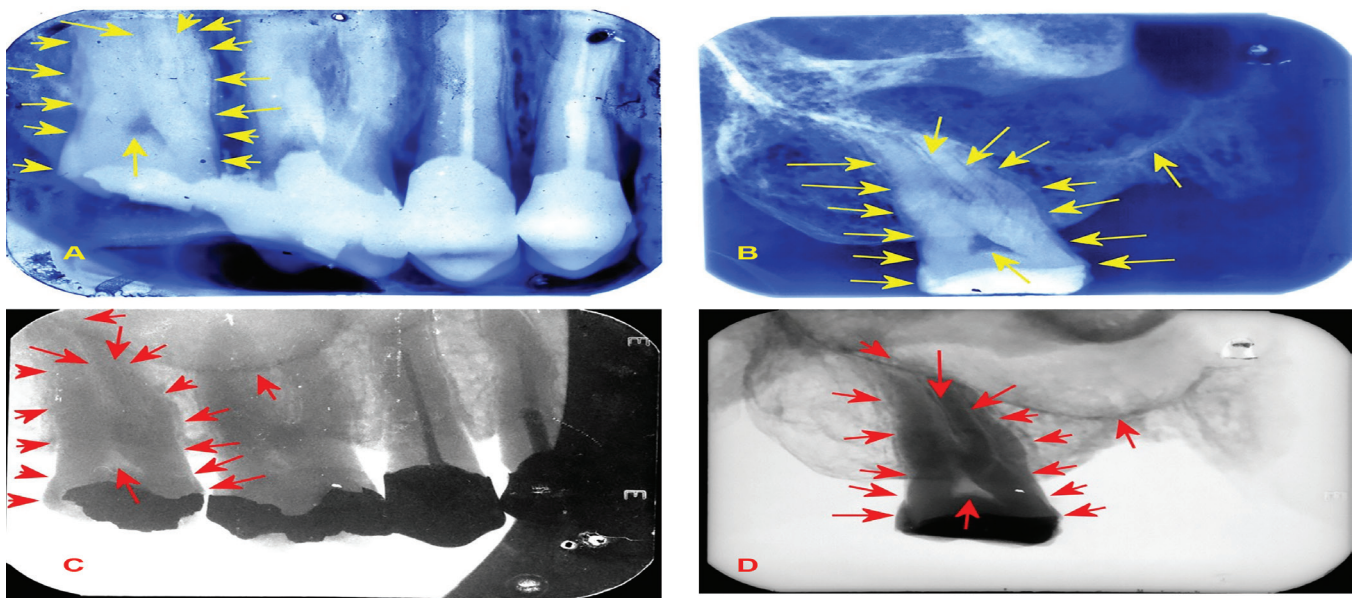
A and C – Antemortem periapical x-rays of dental elements 14, 15, 16 and 17. B and D – Postmortem periapical x-ray of tooth 17. Concordant points in antemortem and postmortem x-rays digitally processed with different image and color settings in the software Corel PaintShop X4.
